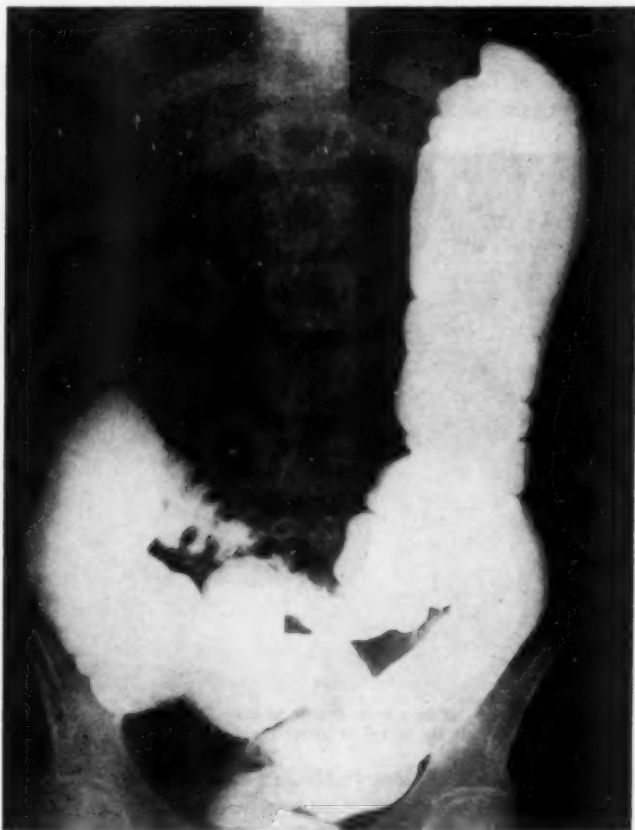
Roentgen appearance of colon following introduction of barium-water mixture by rectal enema. Note the "traplike" arrangement of distal transverse colon and the descending colon (case 19).
